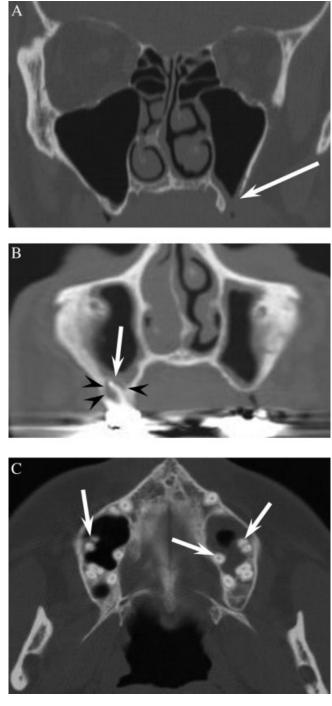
Radiographically evident dental sources of maxillary sinus fluid. (A) Coronal reformatted CT shows a gap (arrow) in the bone of the floor of the left maxillary sinus, indicating oroantral fistula. (B) On coronal reformatted CT, a rim of lucency (black arrowheads) around a tooth root, with an intact covering of bone (white arrow), indicates apical abscess. (C) Axial CT shows tooth roots (arrows) above the floor of the maxillary sinus, but without bony covering, representing projecting tooth roots.
